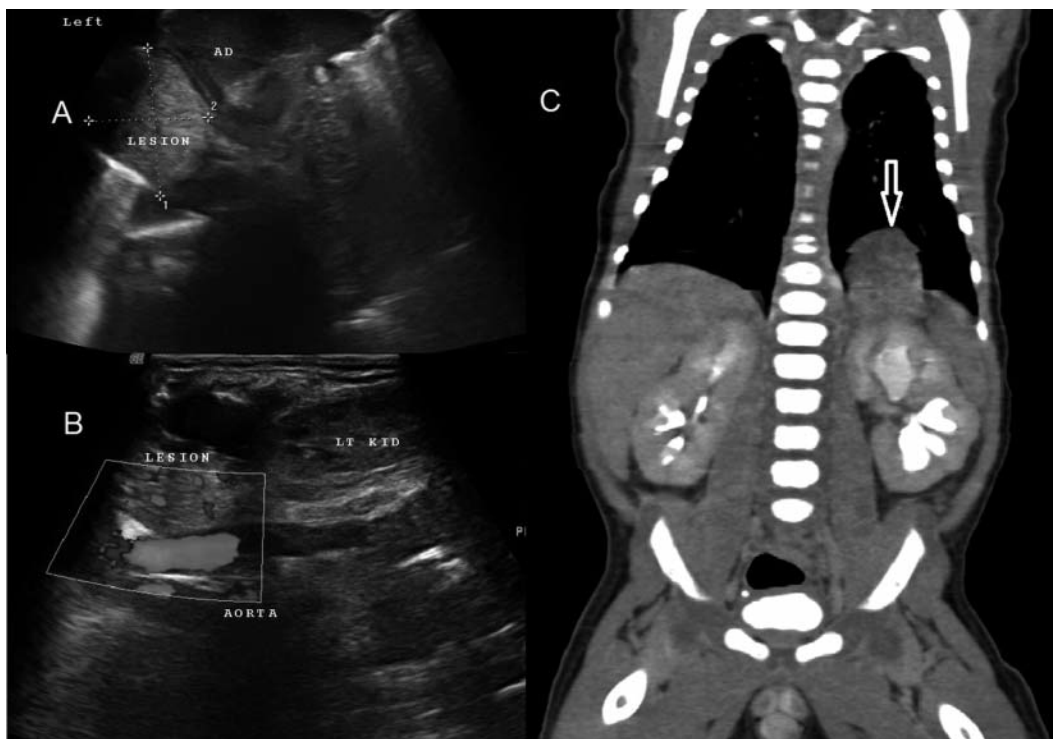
A, B. post-natal ultrasound of infant's abdomen at day 4 of life showing a left supra-renal mass with the feeding vessels from the upper abdominal aorta. C. post-natal CT-scan chest and abdomen of infant at day 5 of life showing a left supra-renal mass.
